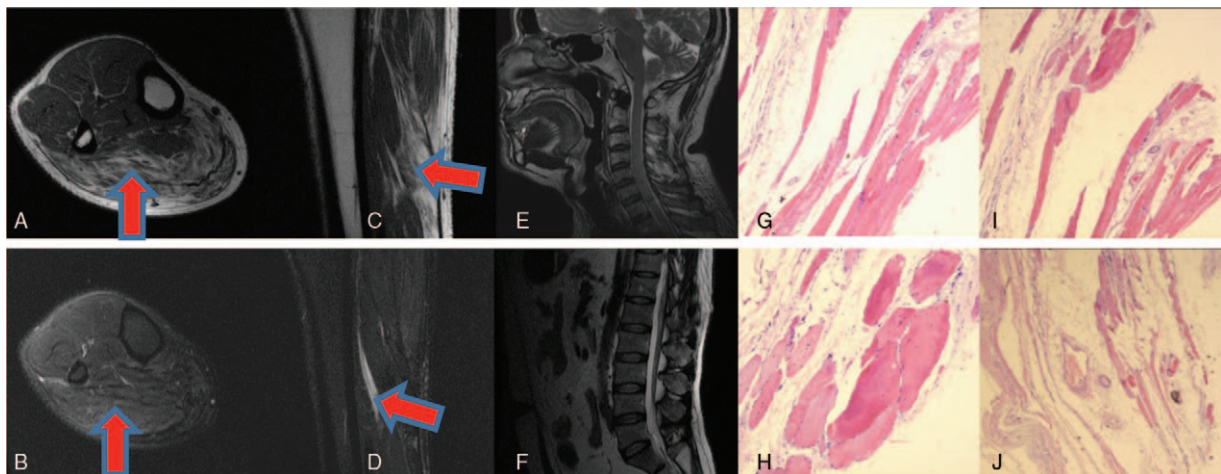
Magnetic resonance imaging (MRI) and muscle biopsy. Muscle atrophy in gastrocnemius muscle and soleus with the fill of adipose tissue between the muscular tissue (A, B, C, and D). Cervical spine and lumbar MRI, demonstrating no obvious abnormality (E and F). The coexistence of muscle atrophy and muscle hypertrophy, the degeneration and necrosis of muscle fiber, and the filling of fat between the muscle fibers (G, H, I, and J).
